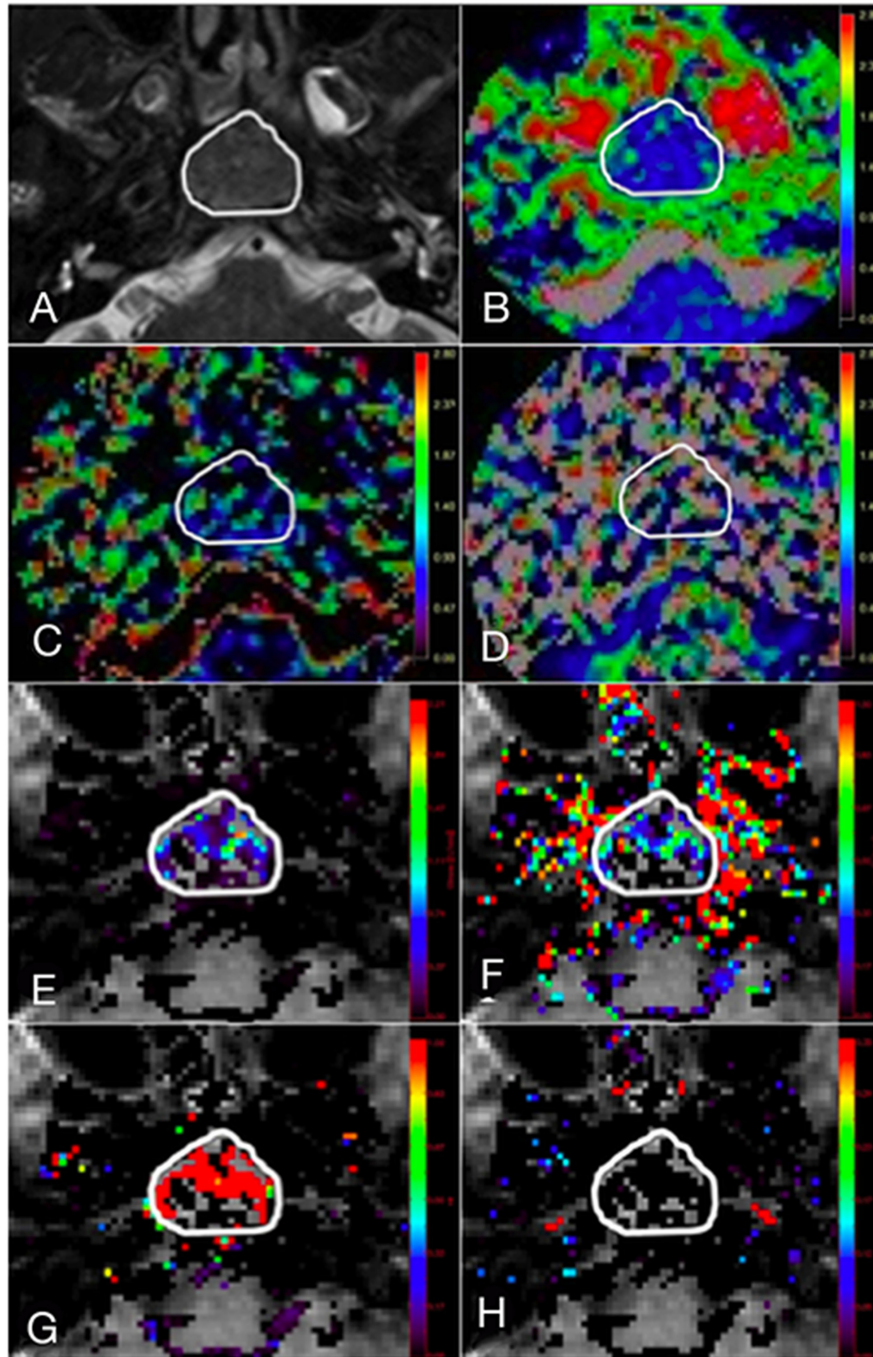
A 45-year-old male with stage T3 NPC. (A) Axial T2-weighted image showing region of interest (ROI) contouring the margin of the NPC, with subsequent co-registration of the ROI onto corresponding (B) diffusion map, D ; IVIM MR perfusion related maps, (C) f and (D) D^* ; quantitative DCE MR perfusion maps, (E) K^{trans} , (F) K_{ep} , (G) V_e and (H) V_p .
